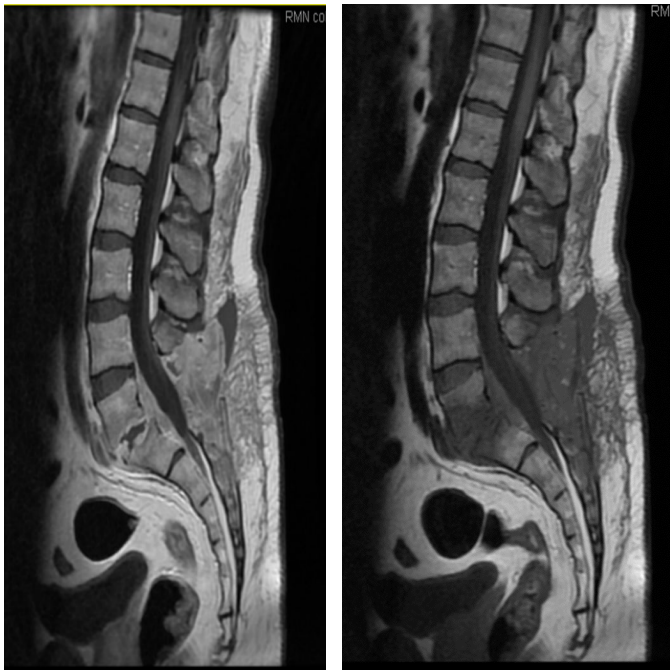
Sagittal T1-MRI of the lumbosacral spine with contrast enhancement
